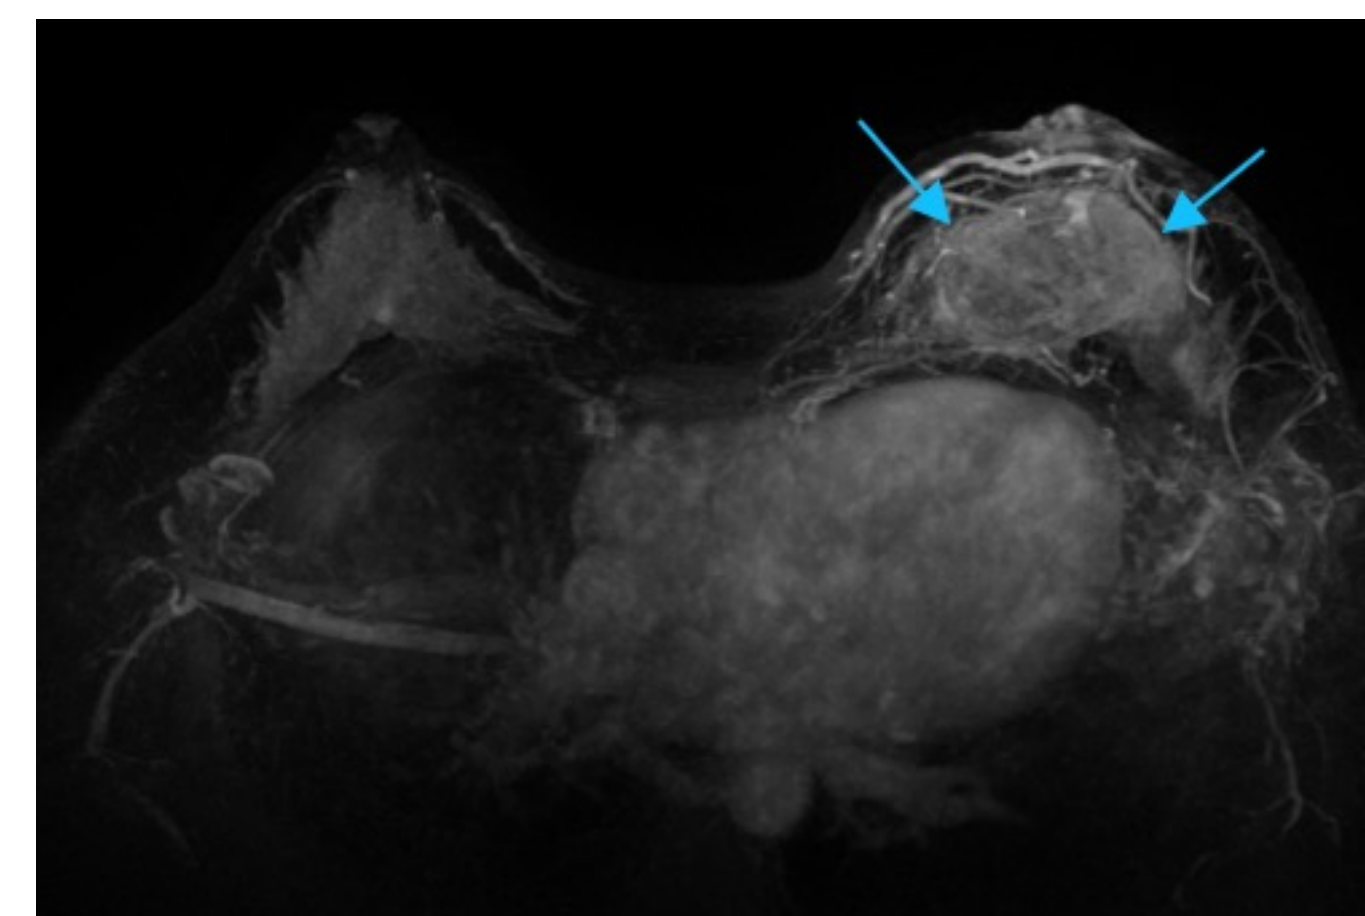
MRI, maximum intensity projection (MIP), demonstrates an irregular breast mass involving the entire central breast (blue arrows). Marked background parenchymal enhancement is otherwise noted bilaterally
